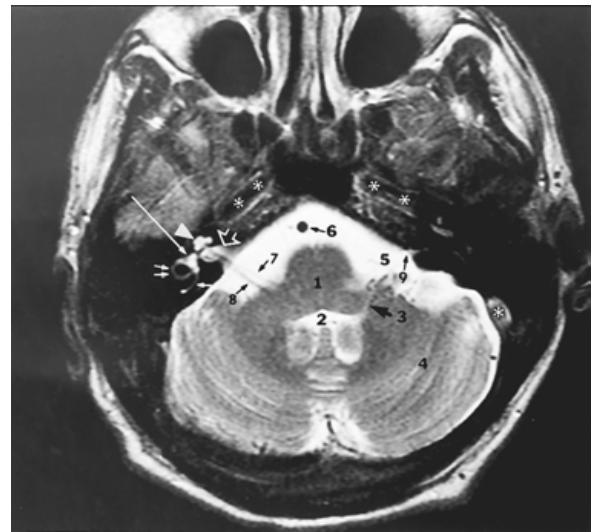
Normal anatomy, axial T2-weighted magnetic resonance image through the inferior portion of the internal auditory canal. 1, brainstem at junction of pons and medulla; 2, fourth ventricle; 3, lateral recess fourth ventricle (foramen of Luschka); 4, cerebellar hemisphere; 5, cerebellopontine angle cistern; 6, basilar artery; 7, facial nerve, cisternal segment; 8, vestibulocochlear nerve, cisternal segment; 9, cochlear aqueduct; single asterisk, sigmoid sinus; double asterisk, carotid canal; open arrow, internal auditory canal with cochlear and inferior vestibular nerves; arrowhead, cochlea (apical and middle turns); long arrow, vestibule; double arrow, lateral semicircular canal; single short arrow, posterior semicircular canal.
